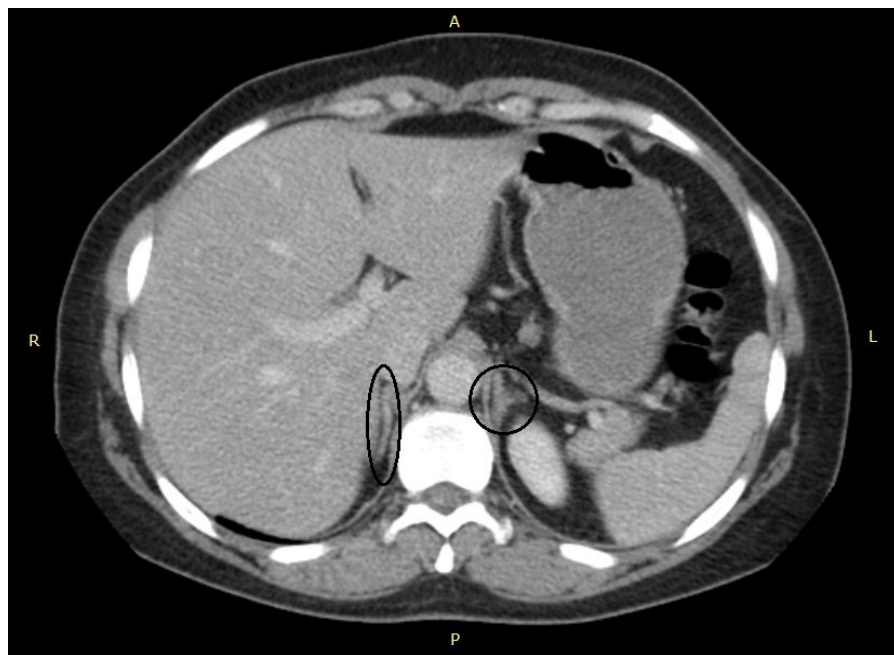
Axial CT image for Male (36 years) shows typical location of both right adrenal gland (linear shape) and left adrenal gland (linear shape).
